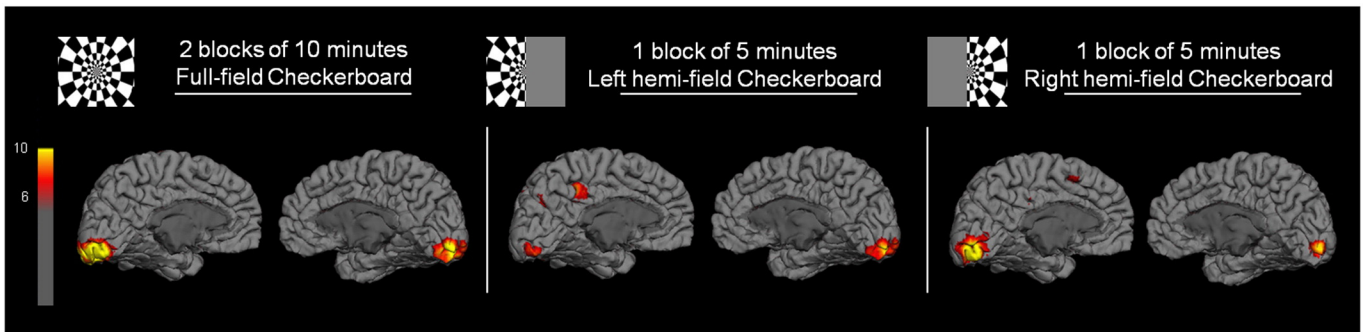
fPET-FDG activations maps for a single subject. Statistical maps (T-score > 6) of the activations observed for a single subject during the two blocks of 10 min full-field checkerboard presentation, the single 5 min block of left hemi-field checkerboard and the single 5 min block of right hemi-field checkerboard.
